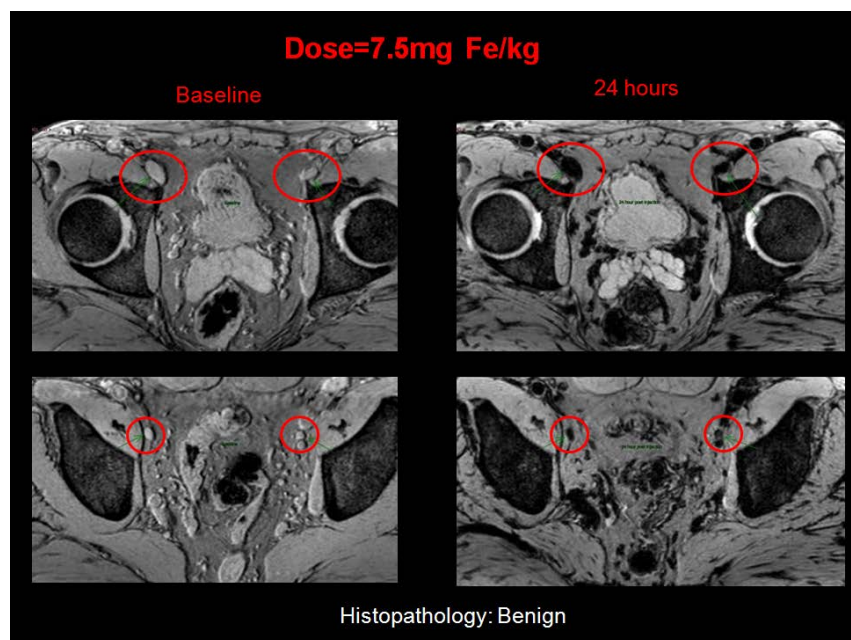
Axial T2* weighted MRI at the baseline scan demonstrates a bilateral iliac chain lymph nodes, 24hr follow up scan after 7.5mg Fe/kg Ferumoxytol injection demonstrate a homogeneous signal drop within the lymph node.
